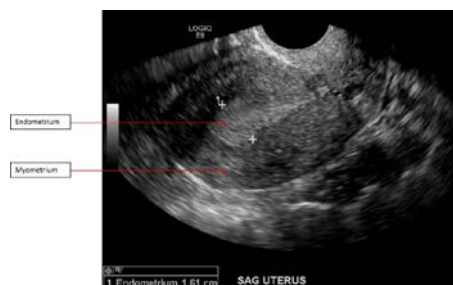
54-year-old female patient presenting with postmenopausal vaginal bleeding. Sagittal image from a transvaginal ultrasound reveals a thickened endometrium measured at 1.61 cm (between calipers). The myometrium is normal. Biopsy confirmed endometrial carcinoma. Courtesy of University of Massachusetts Medical School, Abdominal Imaging Division, UMass Memorial Medical Center.
